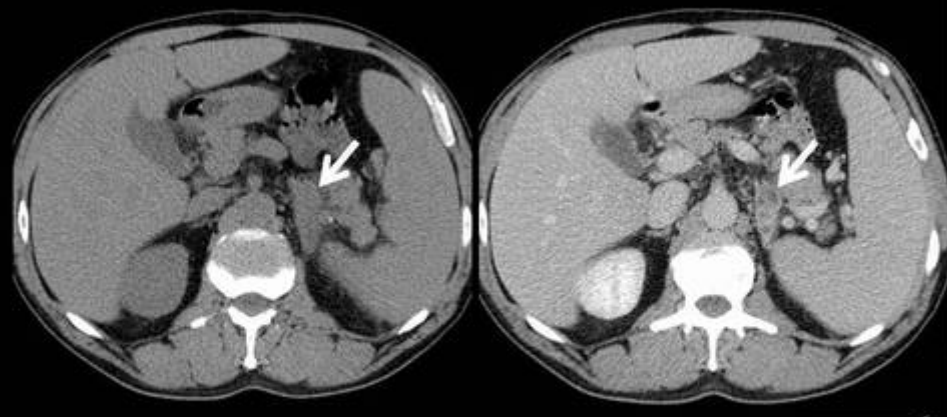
Man, 62 years old, with cerebral tuberculomas. Abdominal CT reveals a mass in the left adrenal, with heterogeneous enhancement due to areas of necrosis.
